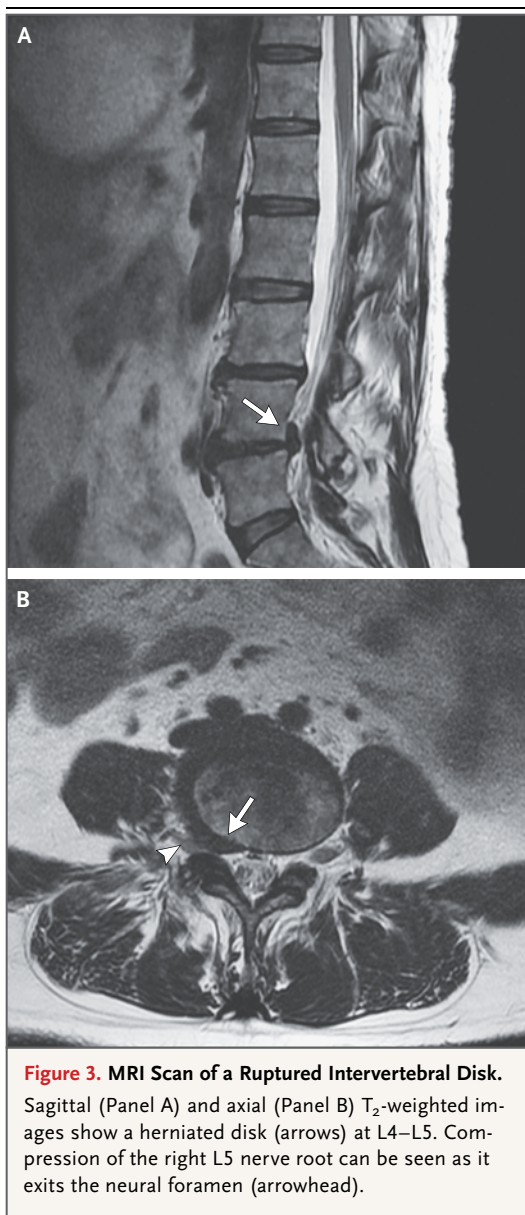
MRI Scan of a Ruptured Intervertebral Disk. Sagittal (Panel A) and axial (Panel B) T₂-weighted images show a herniated disk (arrows) at L4–L5. Compression of the right L5 nerve root can be seen as it exits the neural foramen (arrowhead).
